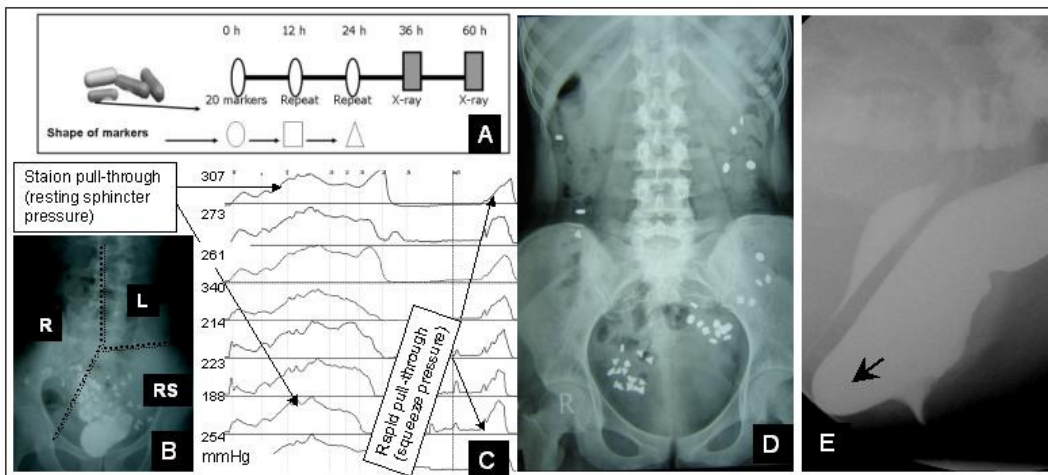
[A]. Protocol for evaluation of colonic transit using radio-opaque markers (SG-mark), in Indian context. [B]. 60-h abdominal radiograph of a patient with constipation studied using such protocol, which shows that most of the markers are retained in the recto-sigmoid segment (RS) suggesting fecal evacuation disorder. Also note that there is retained barium inside rectum from the study done previously, which also suggest evacuation disorder. [C]. Anorectal manometry of the same patient showed very high resting and squeeze sphincter pressure and hence, anismus was diagnosed. The patient improved with repeated sessions of biofeedback and osmotic laxative. [D]. 60-h abdominal radiograph of another patient with constipation studied using SG-mark, which shows that most of the markers are retained diffusely suggesting slow transit constipation. [E]. Defecography of a patient with constipation, showing a large rectocele (marked with an arrow).
